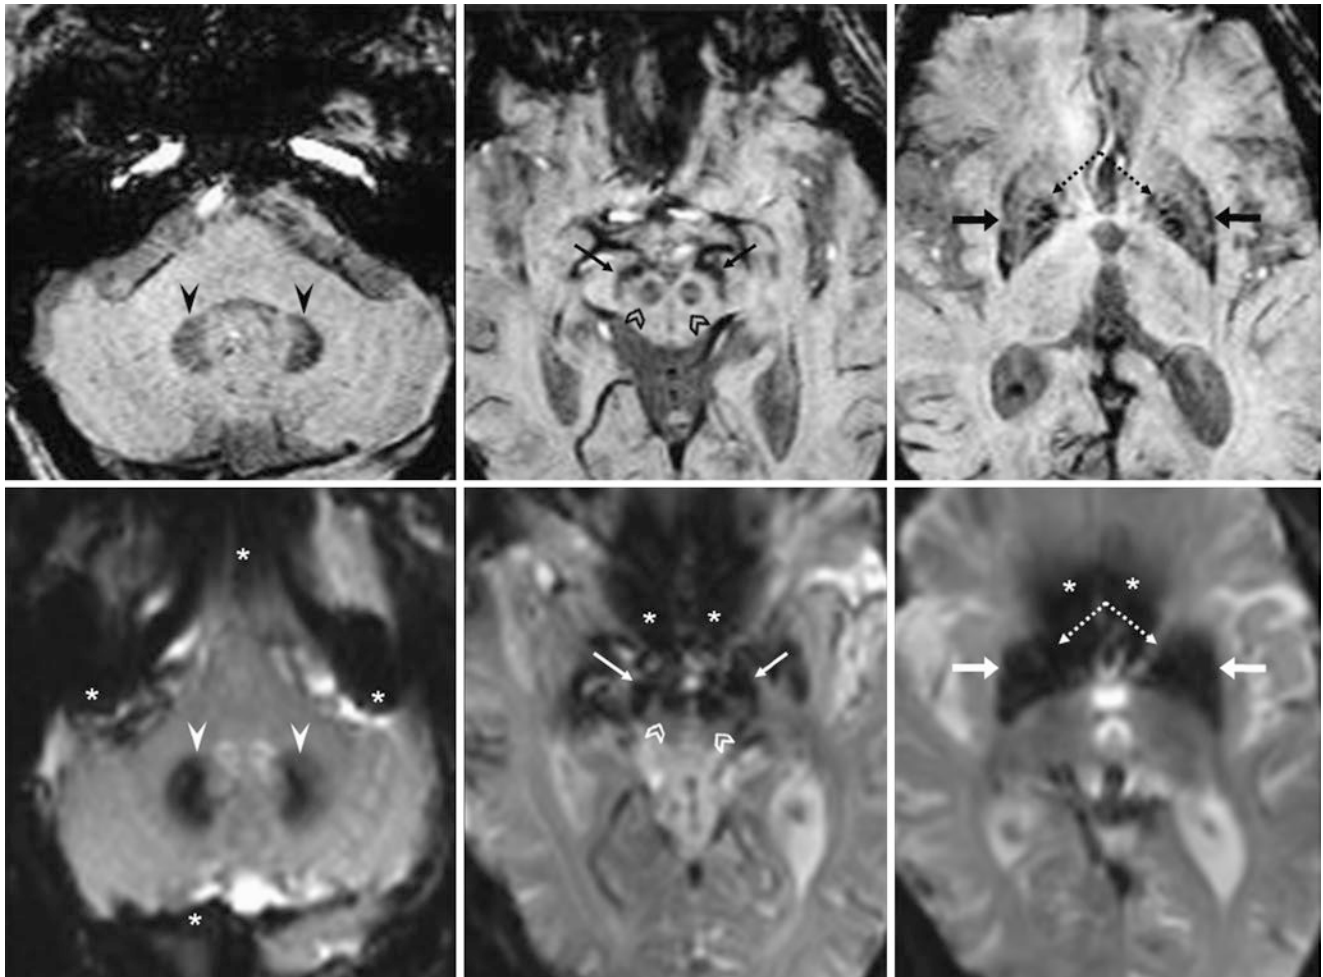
A 76 year old; on a 3T MRI (negative study), SWIs (*top row*) showed a dark signal from iron within the dentate nuclei (*arrowheads*), GP (*dotted arrows*), putamina (*arrows*), and red nuclei (*chevrons*). On matched noncontrast BOLD images (*bottom row*) utilized to
